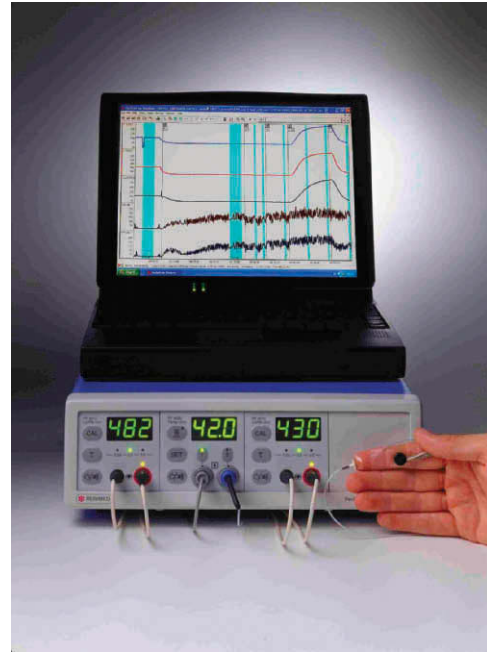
Laser Doppler flowmetry device for the possible detection of pulpal blood flow and vitality.
